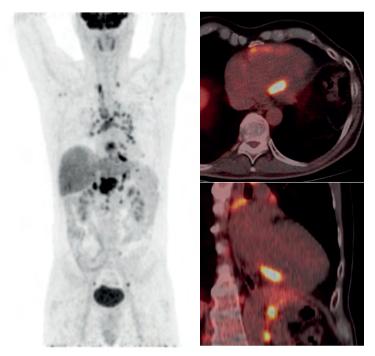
Example of a full body FDG PET/CT with FDG-uptake in the mediastinal, hilar and extrathoracic lymph nodes, lungs (perihilar), liver (diffuse uptake) and heart. The heart shows FDG-uptake in the septum, inferior wall and right ventricle, which is very suspicious for CS localizations.
